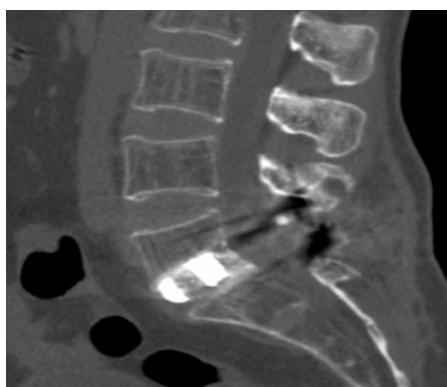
Control CT scan of a 57-year-old female patient 12 months after surgery with trabecular cage implantation and bone block formation
